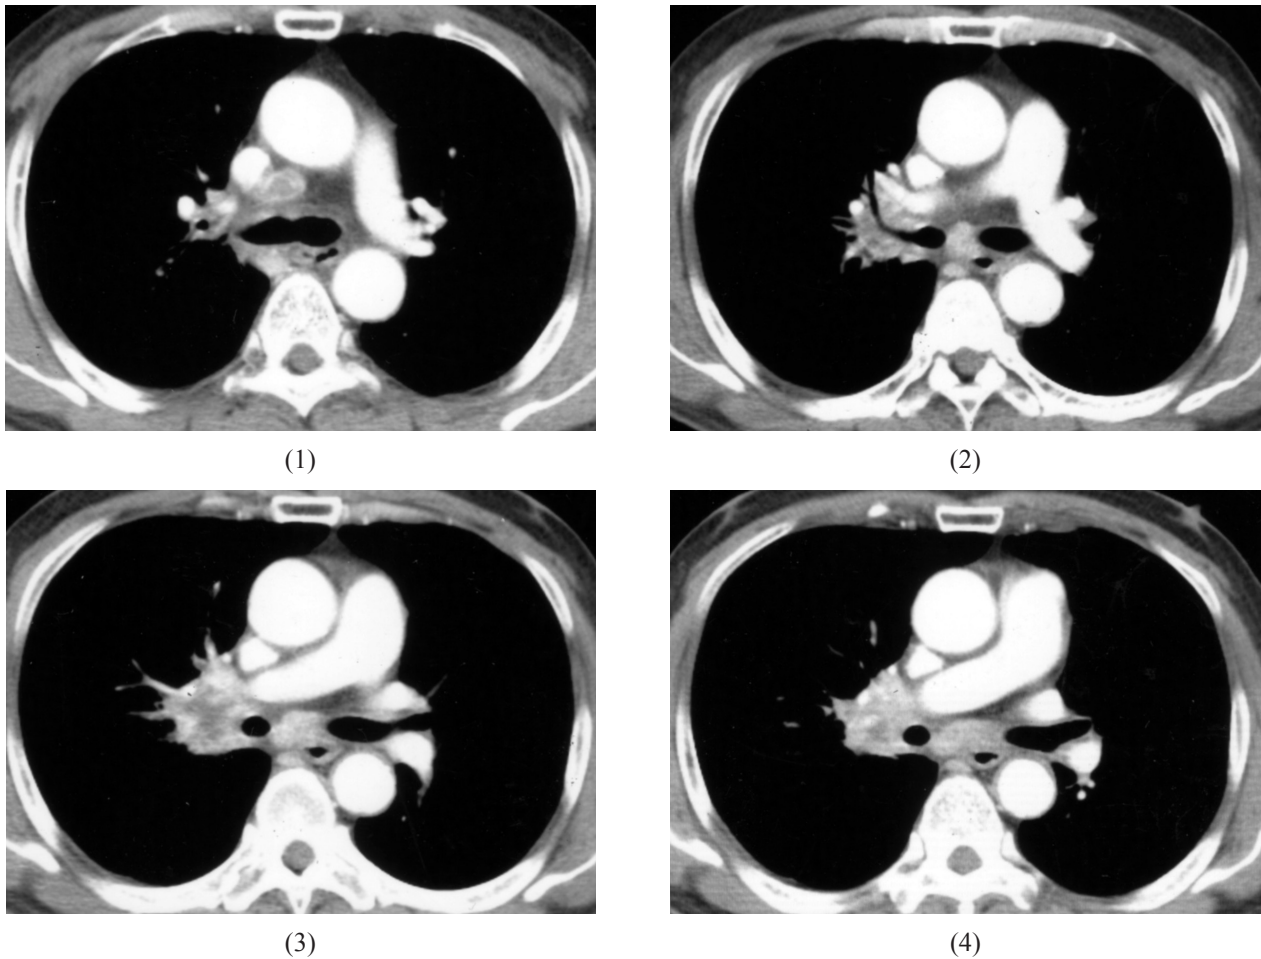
Chest CT scan series showed a mass lesion about 3 cm in diameter in the right hilum, with mildly irregular margination and multiple lymphadenopathies in the right paratracheal, pretracheal and subcarinal regions of the mediastinum, as well as the right parahilar area.
